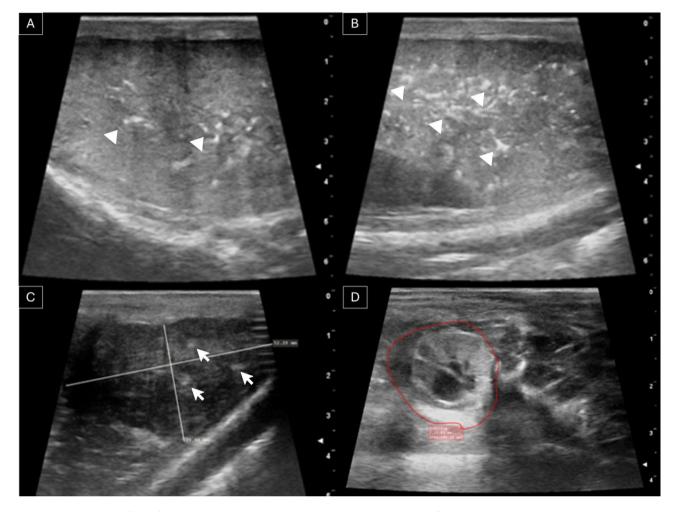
Ultrasonography of the left (A) and right (B) testis, showing moderate and severe testicular fibrosis, as seen by clear hyperechoic spots causing a heterogenous appearance of the testicular parenchym (white arrowheads), respectively. Ultrasonography from the right, enlarged epididymis (C), which contained hyperechoic spots (white arrows). (D) Transrectal ultrasound of large cystic swelling (red circle) dorsal to the pelvic urethra (406.68 mm²) (postmortem). (MyLab[™]SigmaVET, Esaote/Pie Medical, Maastricht, The Netherlands)
